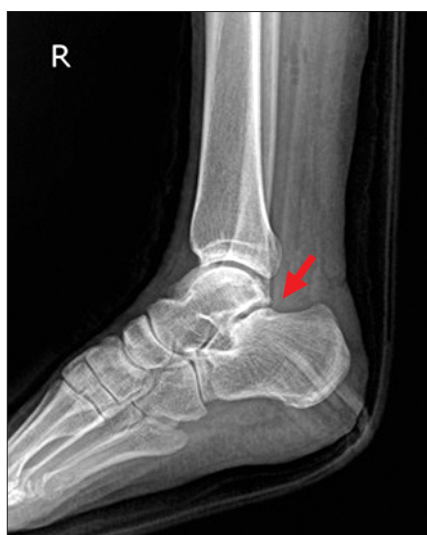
Postoperative radiograph. Osteophyte was removed on lateral view (arrow).
